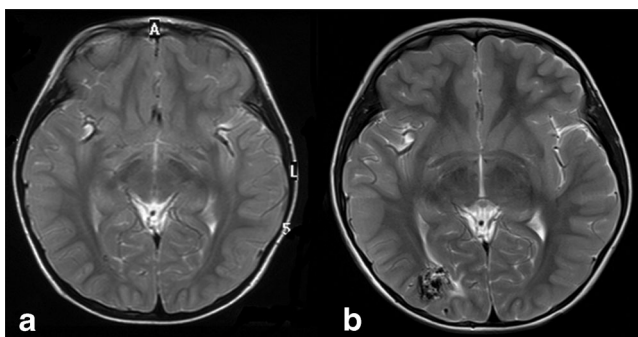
a Axial T2-weighted MRI obtained in 2010; there is no evidence of any vascular lesion. b: Axial T2 MRI obtained in 2013, demonstrating an irregular tangle of vessels in right occipital lobe
